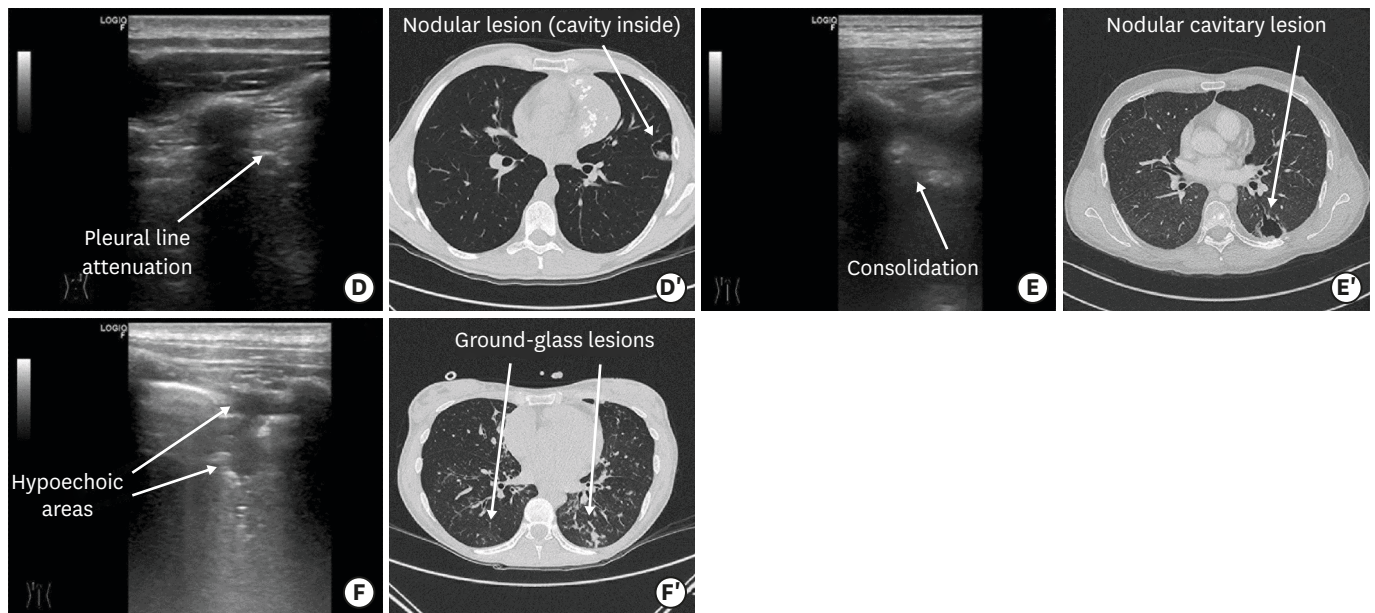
Lung ultrasound images and concomitant computed tomography scan images (UPN 2, UPN 3, and UPN 10). (D) Evidence of a small consolidated hypoechoic area in the left superior lobe with pleural line attenuation corresponding to the affected area (patient UPN 2). (D') Nodular lesion in the superior left lobe (cavity inside; patient UPN 2). (E) One nodular cavity lesion in the inferior left lobe (patient UPN 3). (E') Two consolidated hypoechoic areas in the inferior left lobe (patient UPN 3). (F) Bilateral nodular ground-glass lesions (left > right; patient UPN 10). (F') A scan taken 10 days after the start of antifungal treatment showed smaller consolidated hypoechoic areas in the left inferior lobe and reduction of pleural effusion in comparison to the examination at diagnosis (patient UPN 10).
